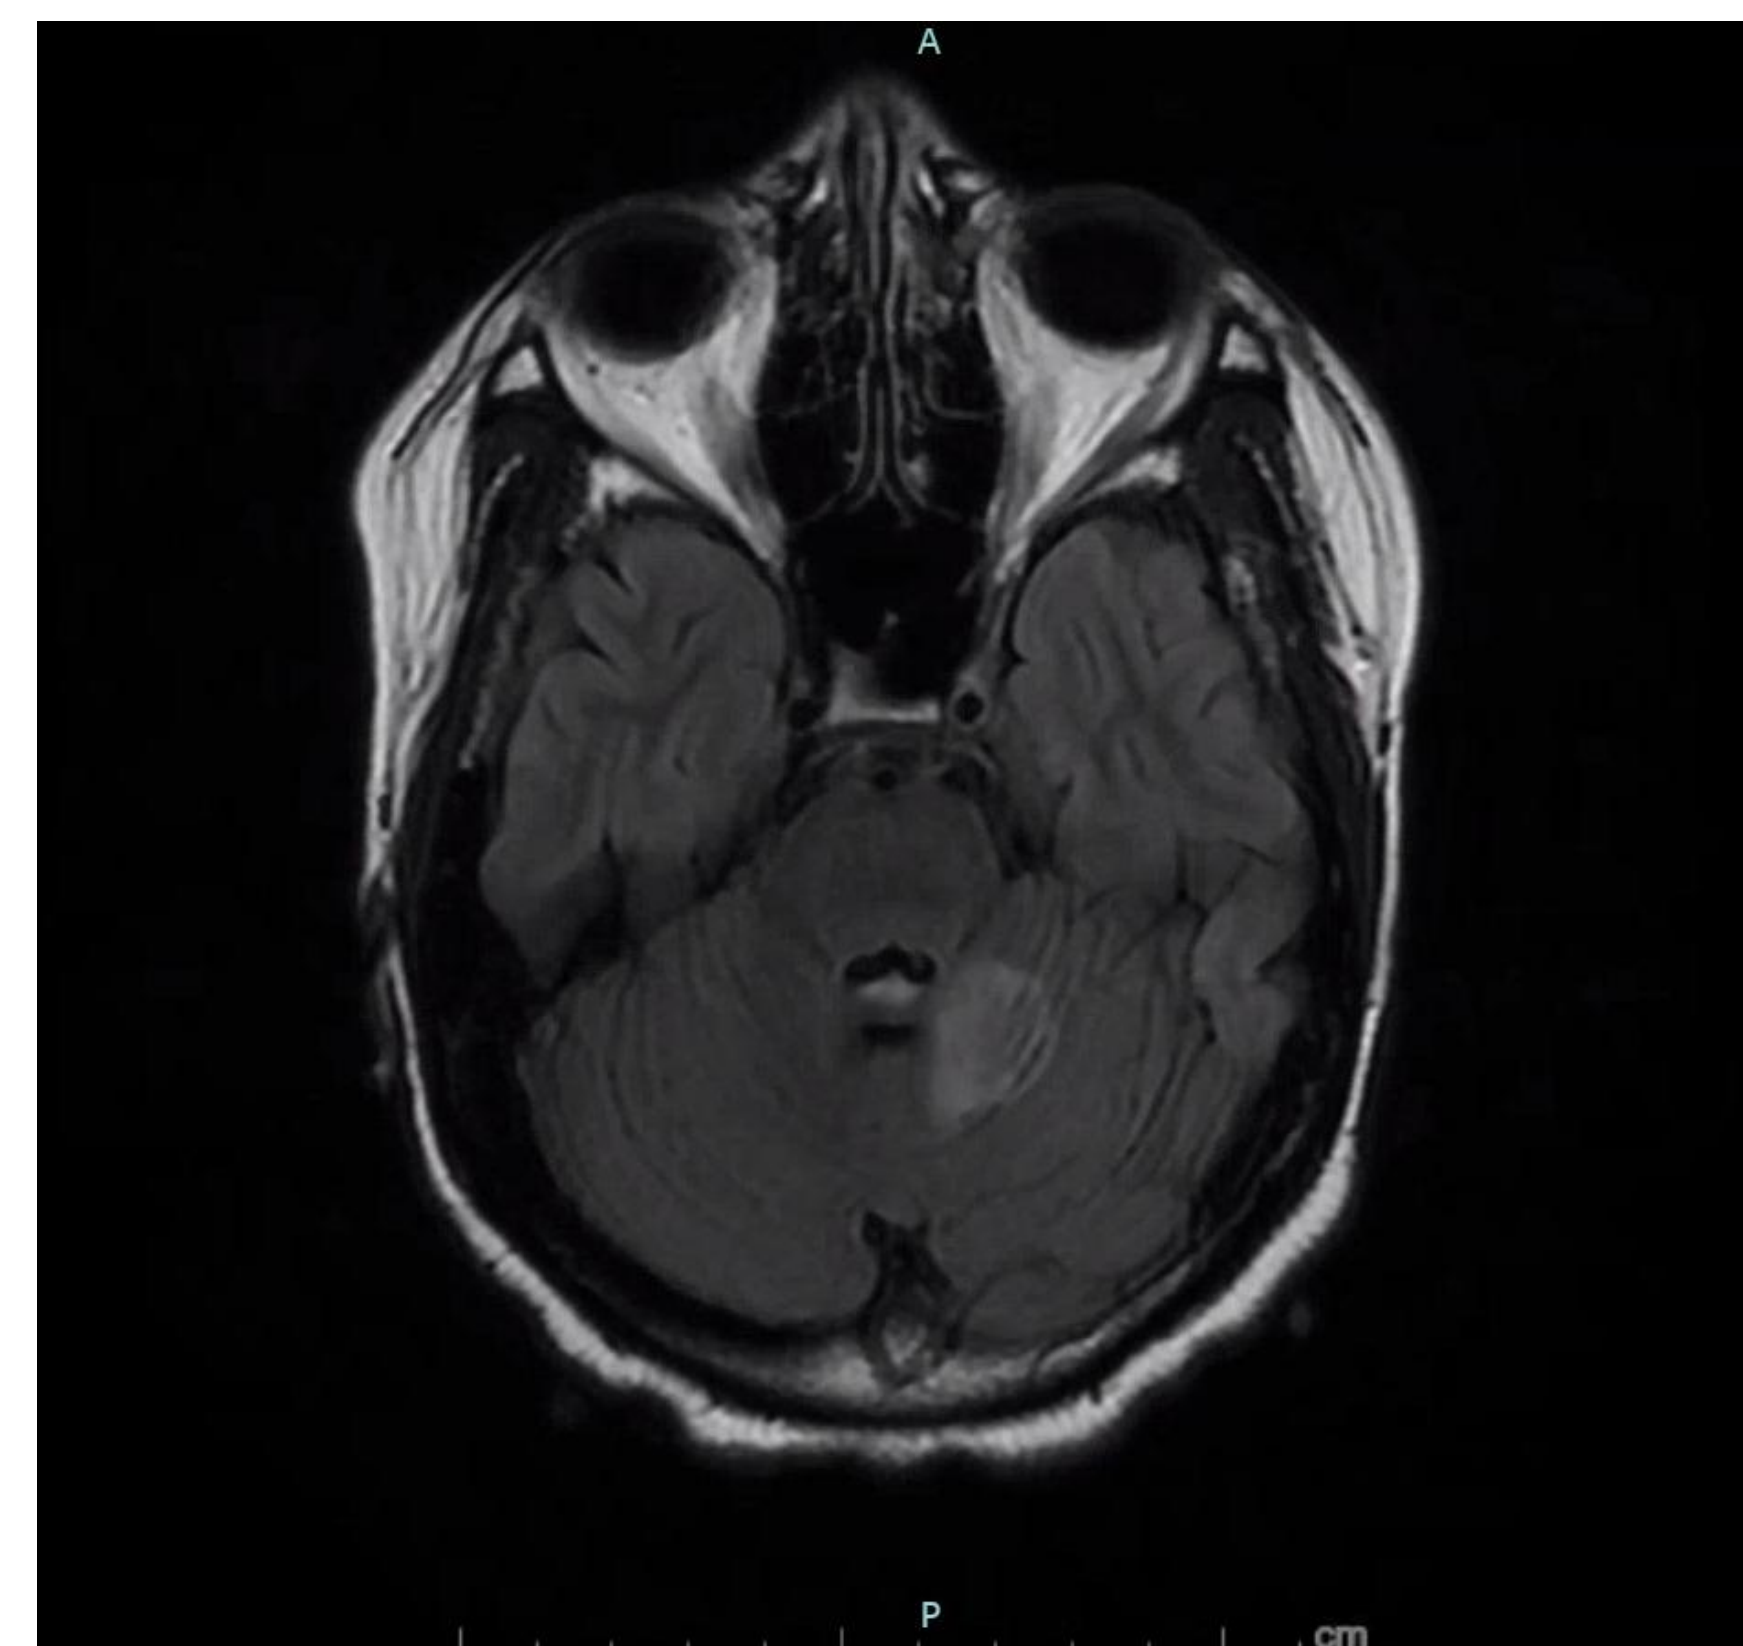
MRI Brain wo contrast, T2 FLAIR after 3 days of treatment
